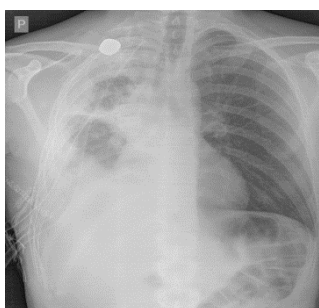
Chest X-ray obtained in the 8th post-operative day, demonstrating an insufficient expansion of the right lung, as well as the remaining bullet in the right supraclavicular region
